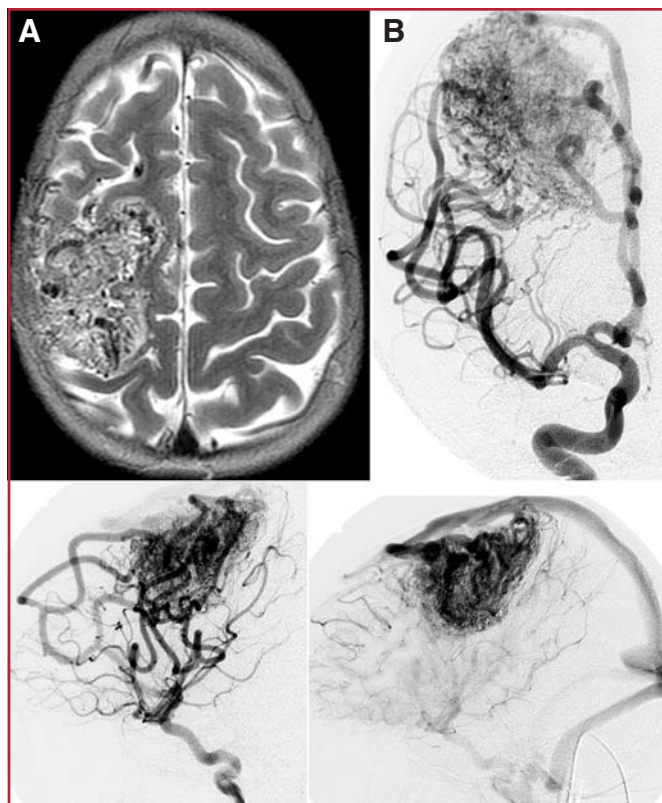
Patient 2. A, MRI scan showing a 7-cm AVM in the frontal lobe bordering the sensorimotor cortex. B, angiograms showing a Spetzler-Martin Grade V AVM.
